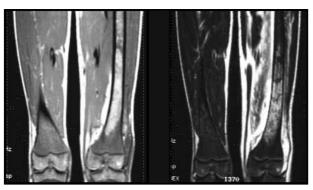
/1. 19 year old patient with sickle cell crisis. [Pseudoosteomyelitis] MRI of the left thigh: A) T1 WI (TR/TE 700/18) reveals high SI in the middle 1/3 of the shaft. Note the high SI of the periosseal soft tissue (arrow). B) T2 WI (TR/TE 3000/96) the SI remains high (hemorrhagic infarct).
